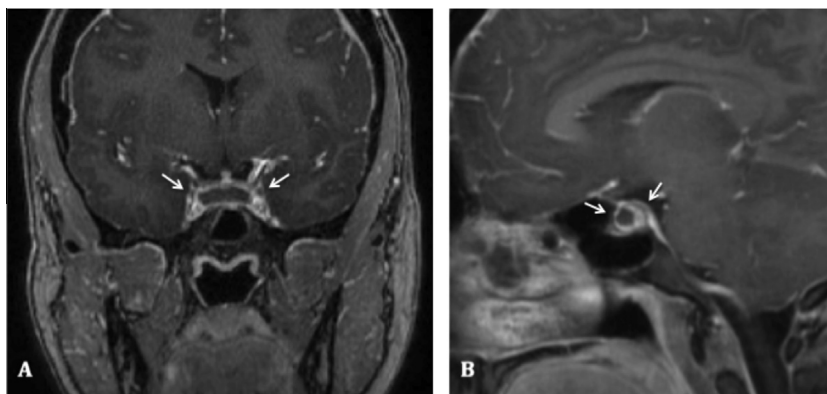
Cranial magnetic resonance imaging scan performed on postpartum day six: T1-weighted coronal (A) and sagittal (B) images post gadolinium enhancement. The pituitary gland (arrows) appears enlarged with peripheral enhancement and an isodense central area.
